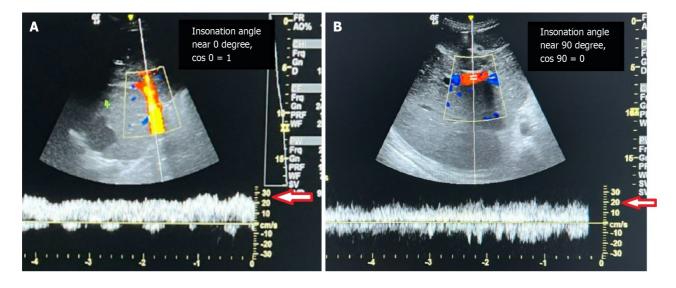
The influence of the insonation angle of the pulse wave spectral Doppler on the flow velocity measurement of the portal vein. A: The left-hand side image showed an insonation angle of near 0 degrees; B: The right-hand side image showed an insonation angle of near 90 degrees for the portal vein of the same patient in the same setting. We underestimated the actual velocity of the portal vein blood flow from about 30 cm/s to roughly 20 cm/s when the insonation angle is near 90 degrees.
